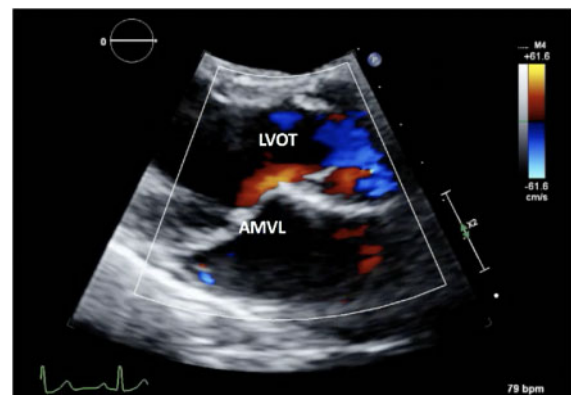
Parasternal long axis with colour Doppler during systole. Note there is no significant mitral regurgitation and there is complete coaptation of leaflets without anterior mitral valve leaflet prolapse. AMVL, anterior mitral valve leaflet; LVOT, left ventricular outflow tract.
